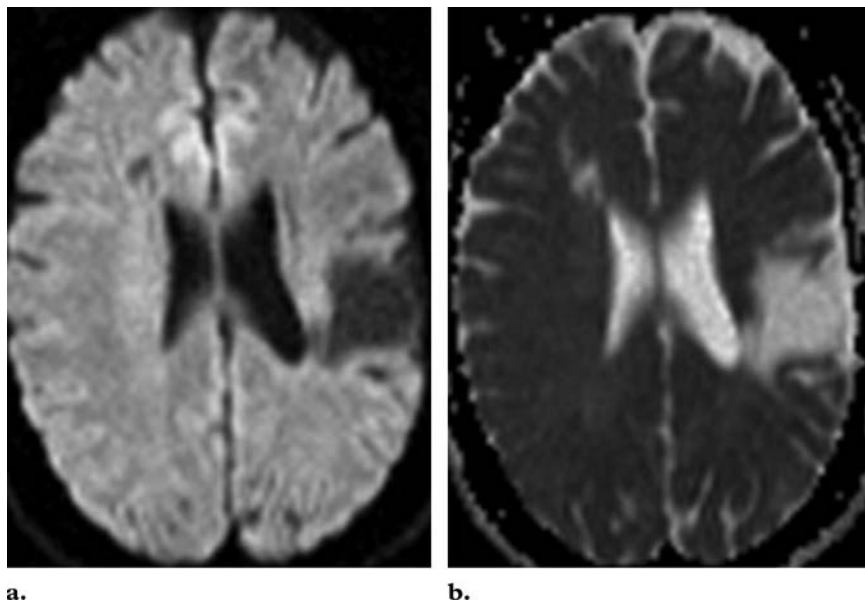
Chronic infarcts in a 71-year-old man with a remote history of multiple strokes. (a) Diffusion-weighted MR image ($b = 1000 \text{ sec/mm}^2$) shows areas of decreased signal intensity in the left frontal lobe. (b) ADC map shows increased ADC values in the white matter of the right frontal lobe. These features are suggestive of chronic infarction.
